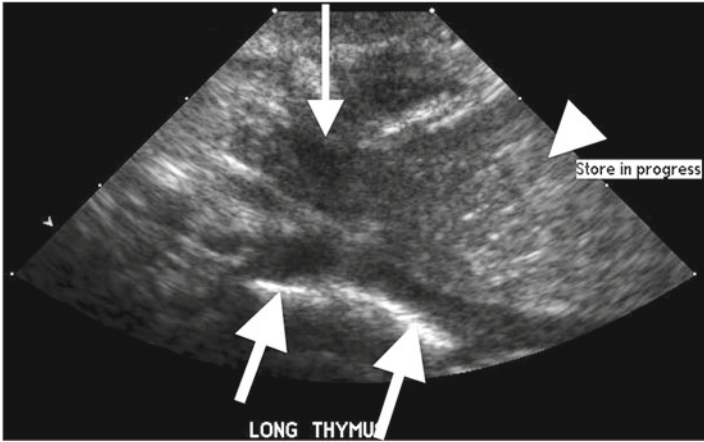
Normal thymus tissue. The thymus may extend well into the neck in younger children and may be confounding when unexpectedly seen on ultrasound. Here a longitudinal US image shows a finger of thymic tissue extending in the neck (*small arrow*), just lateral to the thyroid gland and next to the carotid artery (*large arrows*). Note the normal appearance of the remainder of the thymus (*arrowhead*), which has a similar echotexture as the liver.
